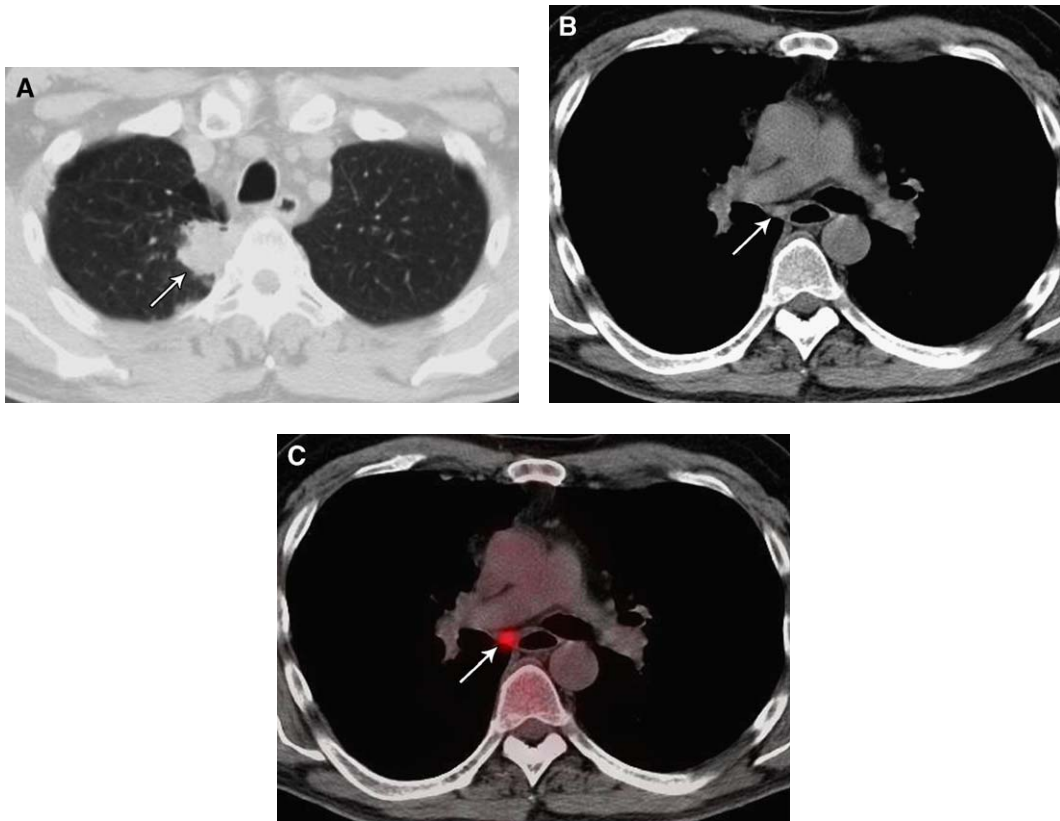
A 55-year-old man with newly diagnosed right upper lobe mass. (A) Lung windows show primary tumor (*arrow*) in right upper lobe. (B) CT scan shows normal-size subcarinal lymph node (*arrow*). (C) Fusion CT and PET image from dual scanner demonstrates increased FDG uptake in subcarinal lymph node (*arrow*) consistent with metastatic nodal disease.
